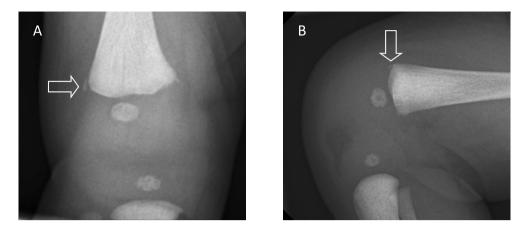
Radiograph AP of the right knee show a classic metaphyseal lesion (arrow). Figure 2b. Radiograph lateral of the right knee show a classic metaphyseal lesion (arrow).
